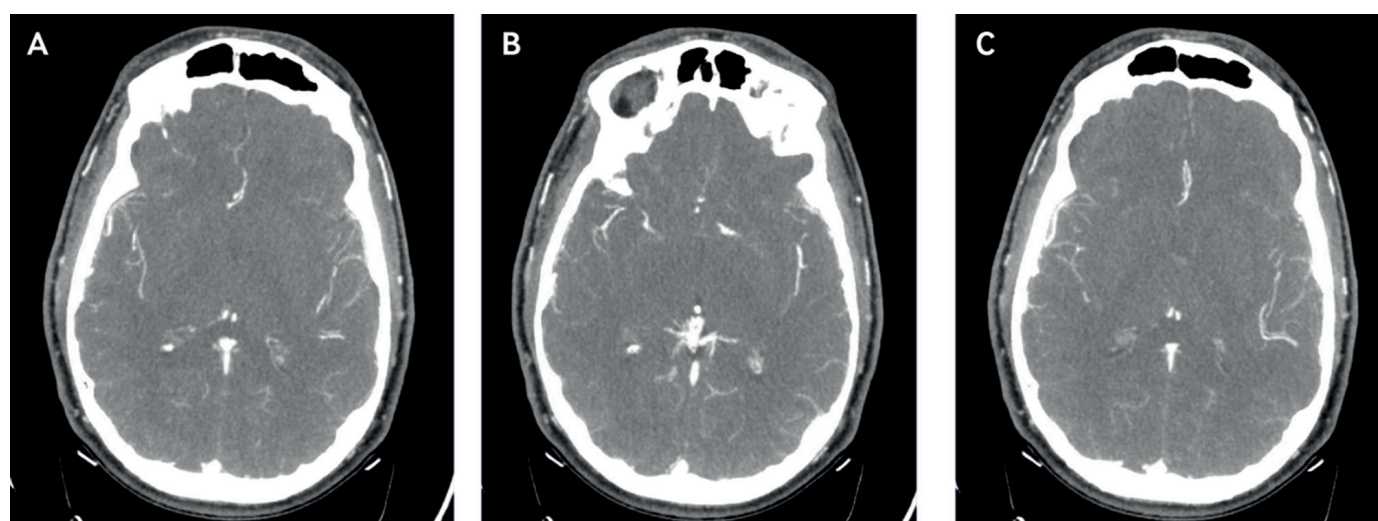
CT angiogram findings of reversible cerebral vasoconstriction syndrome. Irregularity of the intracranial arteries with multifocal narrowing, more conspicuous at the M1 segment of the right middle cerebral artery (A), M2 branches of the right middle cerebral artery (B), A1 and A2 segment of both anterior cerebral arteries (C). Axial images using 0.63 mm slices
